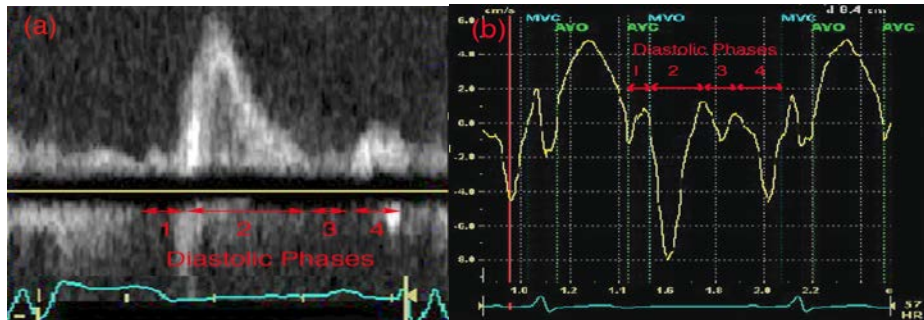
The Four Phases of Diastole shown on a (a) Spectral Doppler trace of mitral inflow (b) Tissue velocity trace of mitral annular motion. (1) Isovolumic relaxation (2) Early passive filling (3) Diastasis (4) Late active filling associated with atrial contraction.
